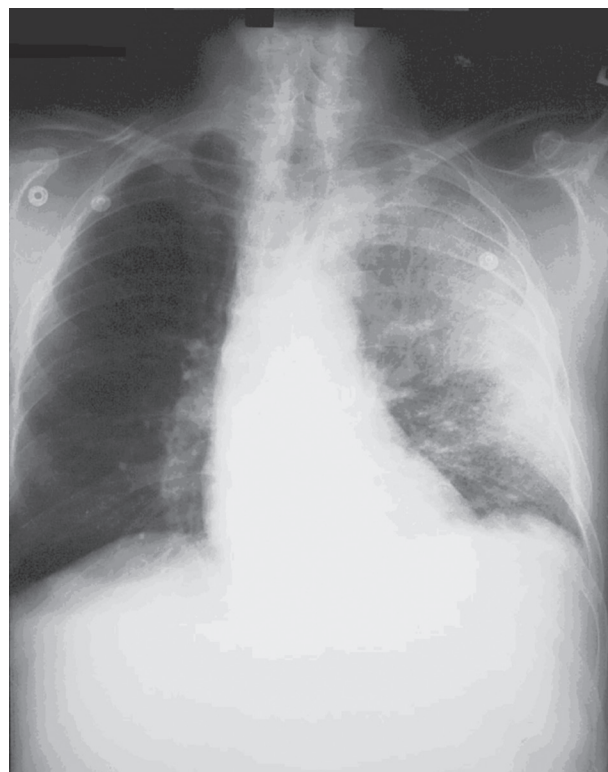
Chest radiograph of anthrax patient showing diffuse left lung consolidation consistent with pneumonia. There is no mediastinal widening. (Courtesy Centers for Disease Control and Prevention [CDC].)
